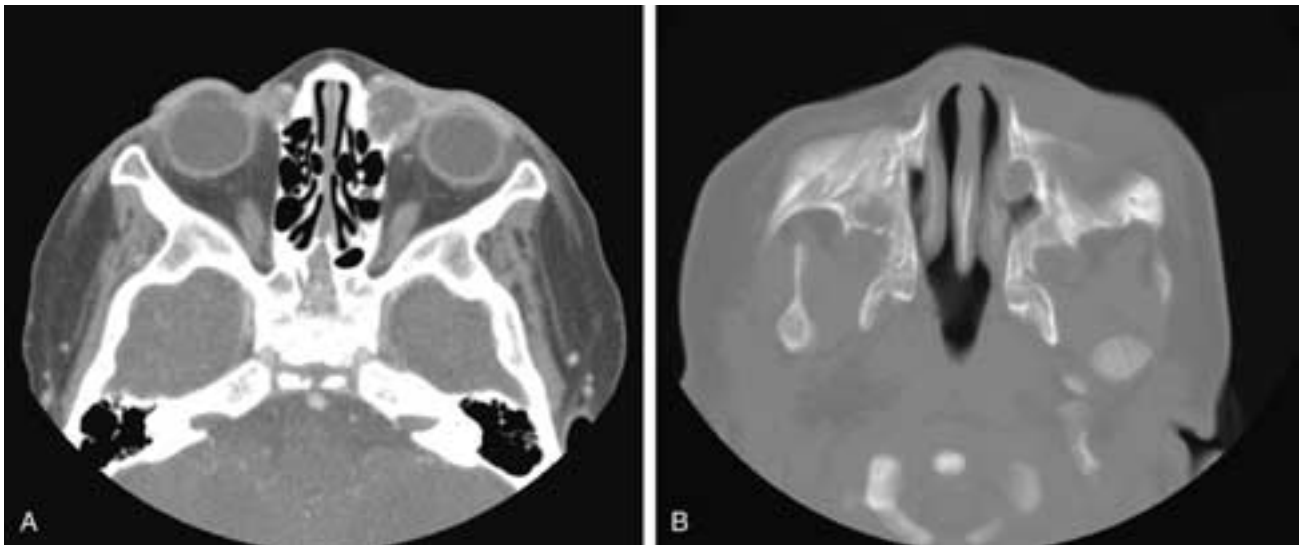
Dacryocystocele. A and B, Axial CT images of a 2-day-old girl with complex cardiac anomalies and asymmetric periorbital edema show asymmetric widening of the left nasolacrimal sac fossa by a tense dacryocystocele. The distended inferior end of the dacryocystocele protrudes into the nasal cavity, causing partial obstruction.
